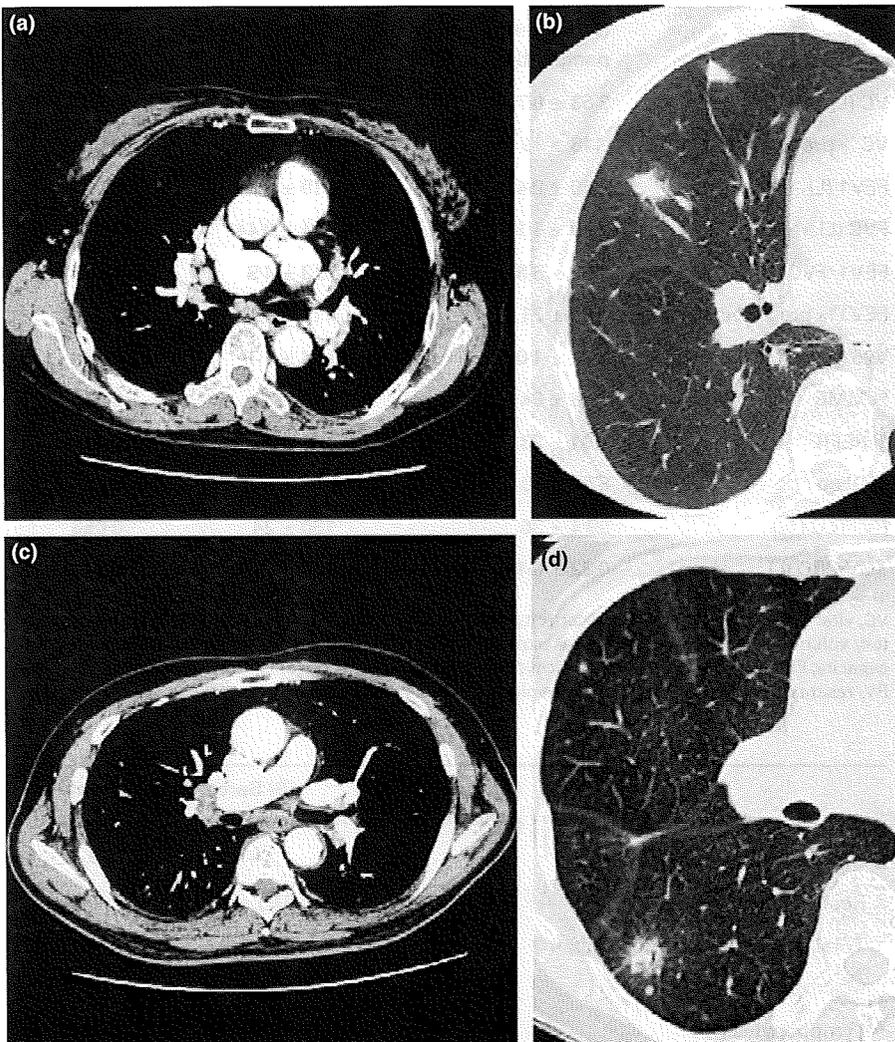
(a) A 78-year-old female with autoimmune pancreatitis showed bilateral hilar lymphadenopathy and an enlargement of the mediastinal lymph nodes on chest CT scans. (b) The same patient showed consolidated nodules with spiculation in the right lower lobe and the inguinal lobe. (c) A 65-year-old male with autoimmune pancreatitis showed unilateral lymphadenopathy and enlargement of the mediastinal lymph nodes on chest CT scans. (d) A 73-year-old female with autoimmune pancreatitis showed nodule with spiculation in the right lower lobe and fine nodule in the right upper lobe.
